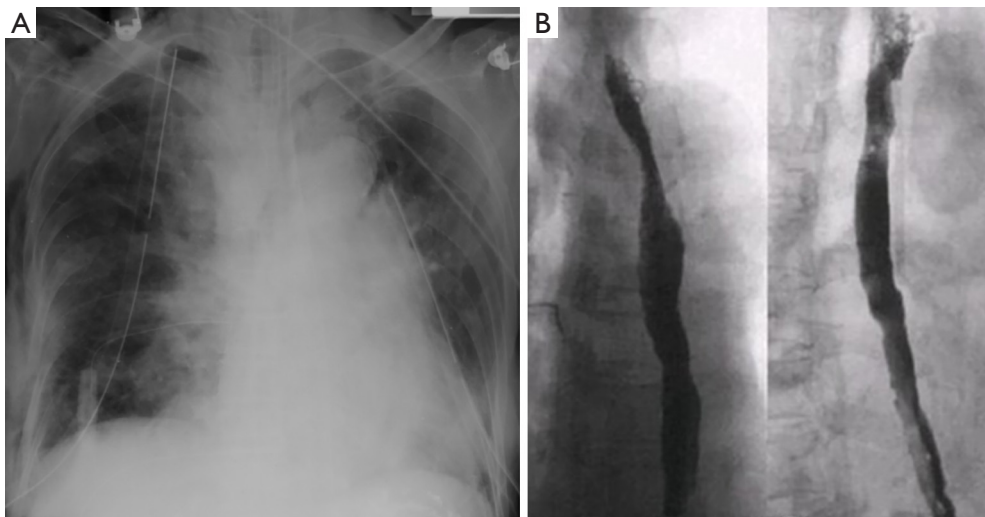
Postoperative findings. (A) Postoperative chest radiograph showed (I) two chest tubes in the right side: one was to the lung apex tracing the lateral part of the chest cavity and the other was near the perforated site for drainage, and (II) a chest tube in the left side: it was inserted in the Surgical Intensive Care Unit due to the pleural effusion; (B) postoperative esophagogram with barium showed no leakage of the perforated site of esophagus.
